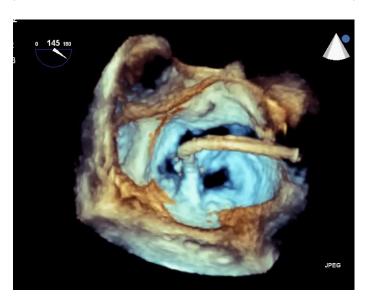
The MitraClip procedure requires optimal visualisation by 2D and 3D echocardiography.
